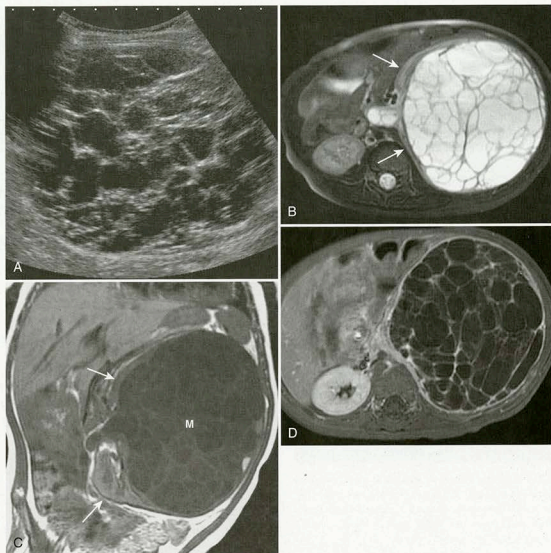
Multilocular cystic nephroma. A, Ultrasound shows a multiloculated cystic mass in the left kidney. B, T2-weighted, axial MR image shows multiseptated cystic mass. Note “claw sign” indicating origin of mass in left kidney (arrows). C, T1-weighted, coronal MRI shows low signal in cystic structures within mass (*M*). Again, note renal parenchyma (arrows) surrounding the medial aspect of the mass. D, Postcontrast, axial MR image shows only septal enhancement of cyst walls without solid components.
